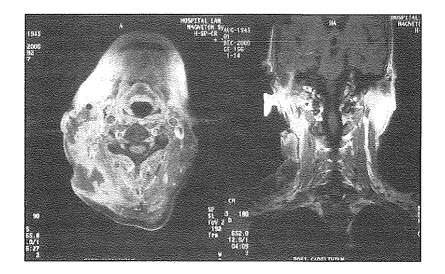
MRI scan showing right mastoiditis and deep abscess extending down to the neck.
